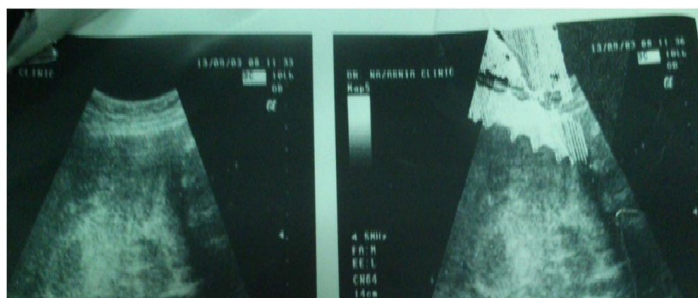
Trans abdominal sonogram of a pelvis revealing a large heterogeneous calcified well defined mass in the right region of pelvis
